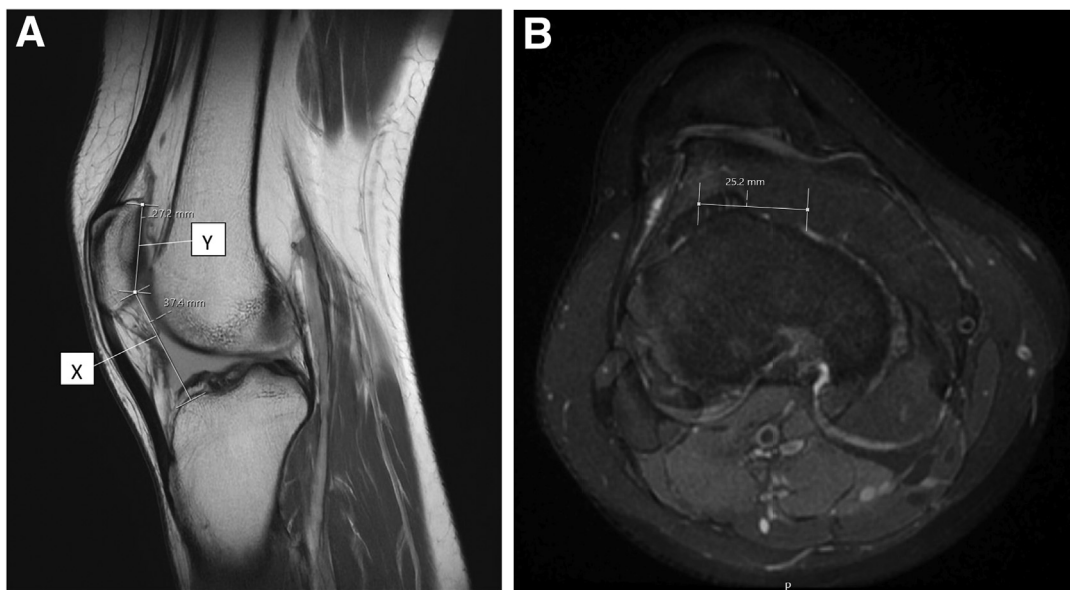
(A) A slice of a sagittal view of magnetic resonance imaging (MRI) of a right knee. The measurement lengths represent the Caton-Deschamps Index (CDI), which is the ratio of (X) the length from the anterior angle of the tibial plateau to the most inferior aspect of the patellar articular surface and (Y) the length of the patellar articular surface. $CDI \geq 1.2$ indicates patella alta in the patient. This patient has a CDI of $37.4/27.2 = 1.375$. (B) Two superimposed axial slices from MRI of a right knee. The measurement taken is of the distance between the tibial tubercle and the trochlear groove (TT-TG). A TT-TG of greater than 15 mm predisposes the patient to patellar instability. This patient has a TT-TG of 25.2 mm and thus should be indicated for patellar realignment.
